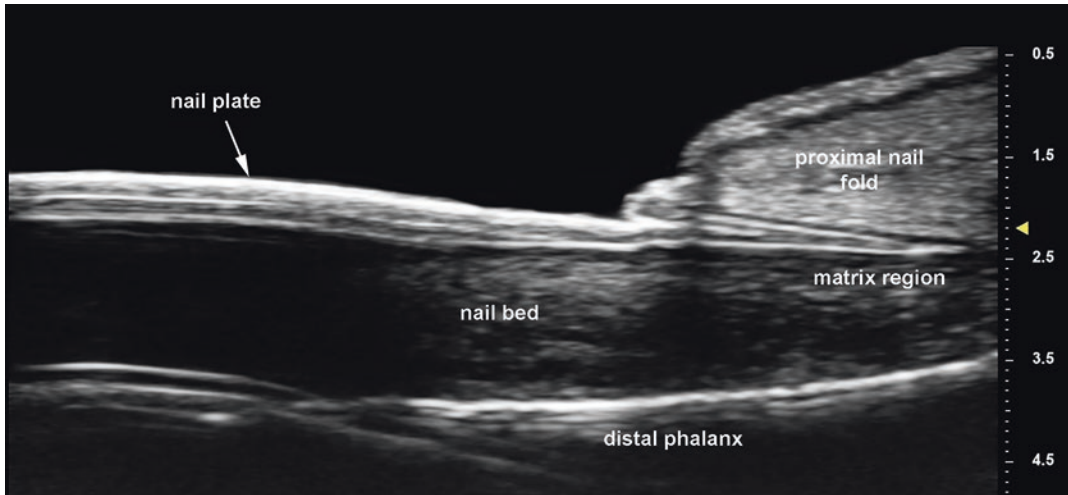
Normal ultrasound anatomy of the nail using a 70 MHz maximum frequency probe (longitudinal view)
